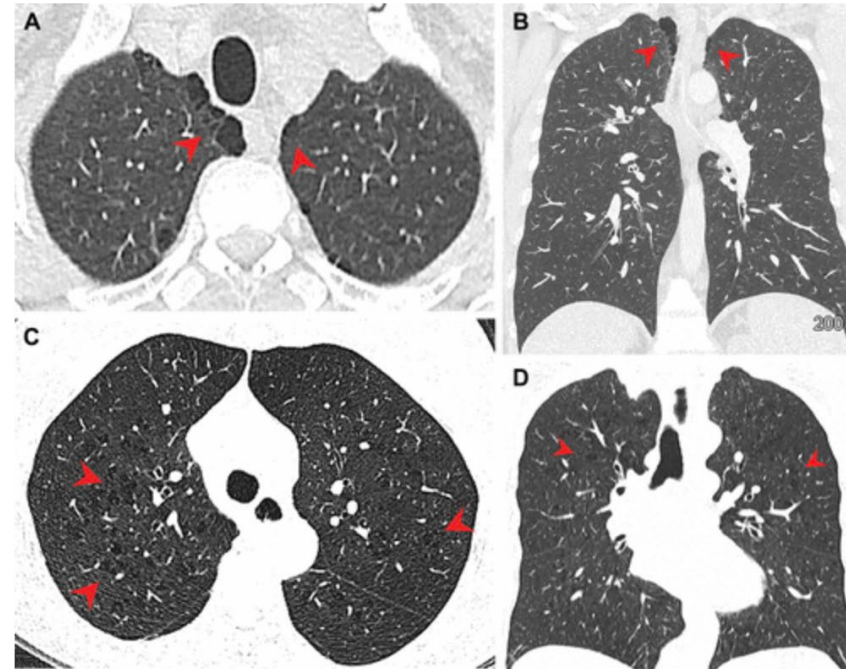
Pulmonary emphysema in (A, B) marijuana and (C, D) tobacco smokers. (A) Axial and (B) coronal CT images in a 44-year-old male marijuana smoker show paraseptal emphysema (arrowheads) in bilateral upper lobes. (C) Axial and (D) coronal CT images in a 66-year-old female tobacco smoker with centrilobular emphysema represented by areas of centrilobular lucency (arrowheads).
